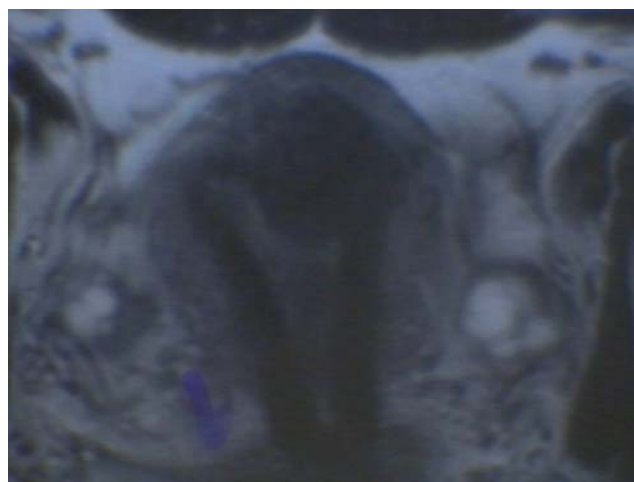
MRI of the submucous fibroid 5 mm from serosa
